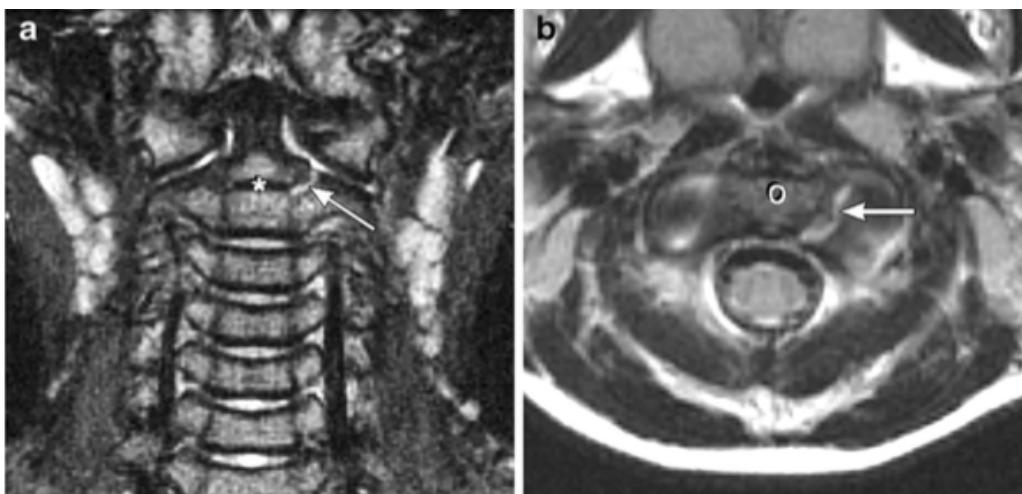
Type IV fracture patient 12, a 2-year-old girl after motor vehicle crash. (a) Coronal and (b) axial MRI images obtained with patient in cervical collar show fracture line with bright T2 signal edema extending through only the left odontoneural synchondrosis (arrow) adjacent to the odontoid (o). The odontocentral synchondrosis (*) is intact. There was also associated apical and left atlantodental ligament injury with edema noted along the C1-C2 facets, body of C2 and left C2 neural arch (not shown). The girl was treated with cervical collar stabilization only.
